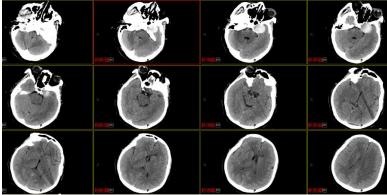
Emergency cranial CT on admission showing a round hyperdense lesion in the left parasellarregion.
